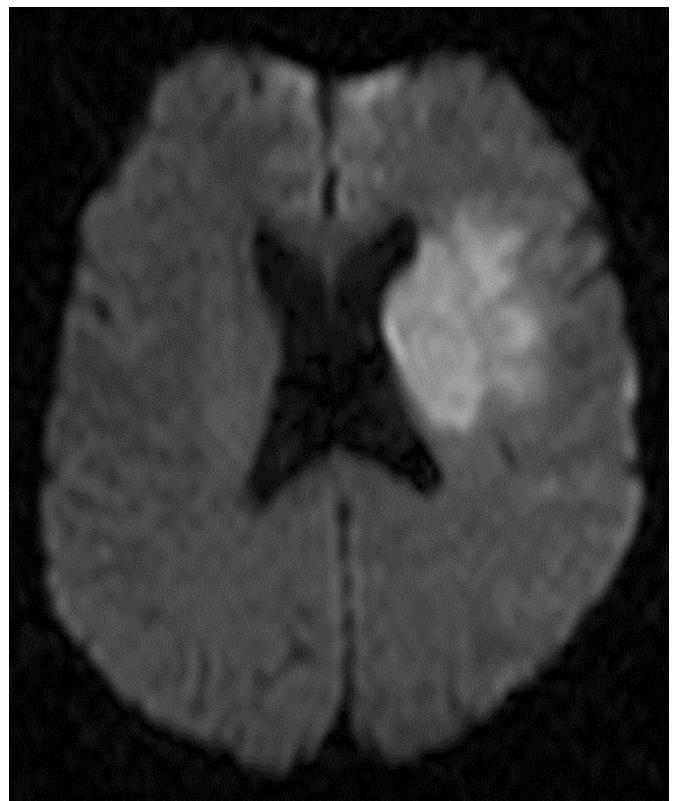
MRI with ischemic stroke in the territory of the left middle cerebral artery.
